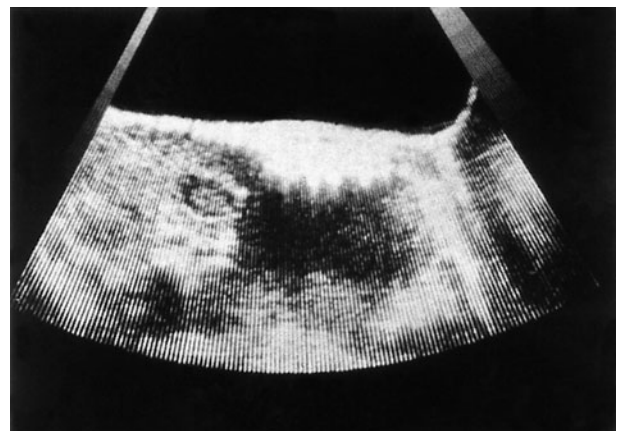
Longitudinal real-time sonogram section reveals hypoechoic ring with echogenic center typical of pyloric tumor.
